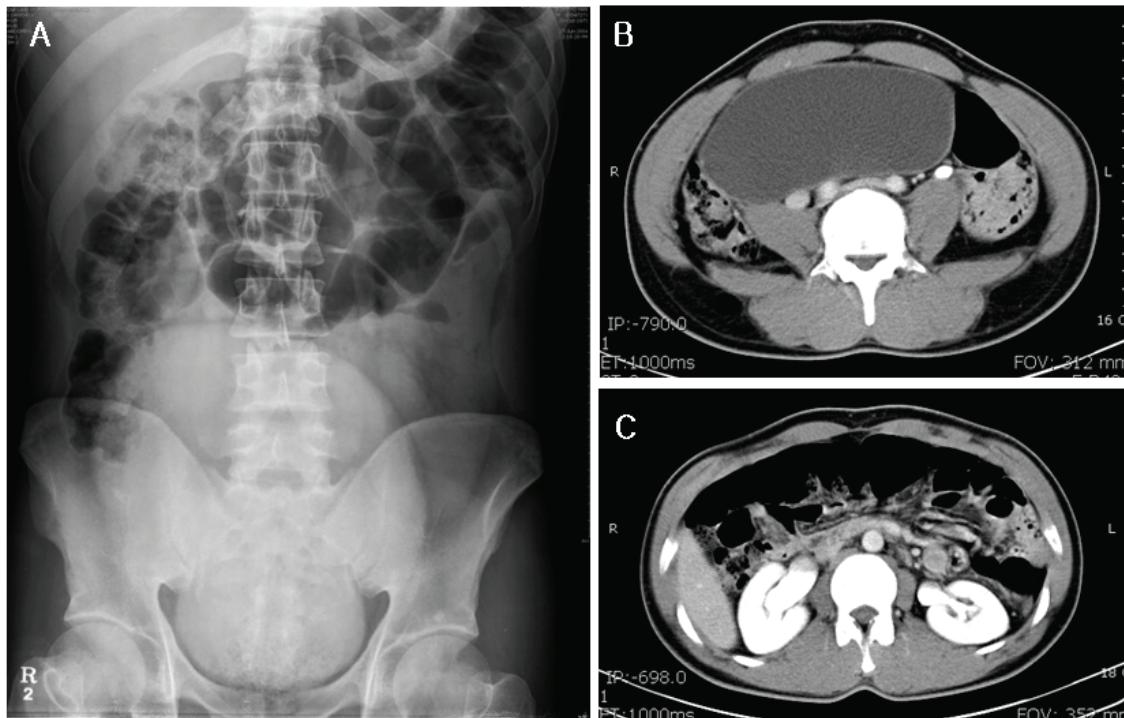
Simple flat abdominal x-ray of the proband showing ileus and distension in the bladder (A). The abdominal computed tomograph also showing distension of the bladder (B), and hydronephrosis and hydroureter on both sides of the kidney (C).
